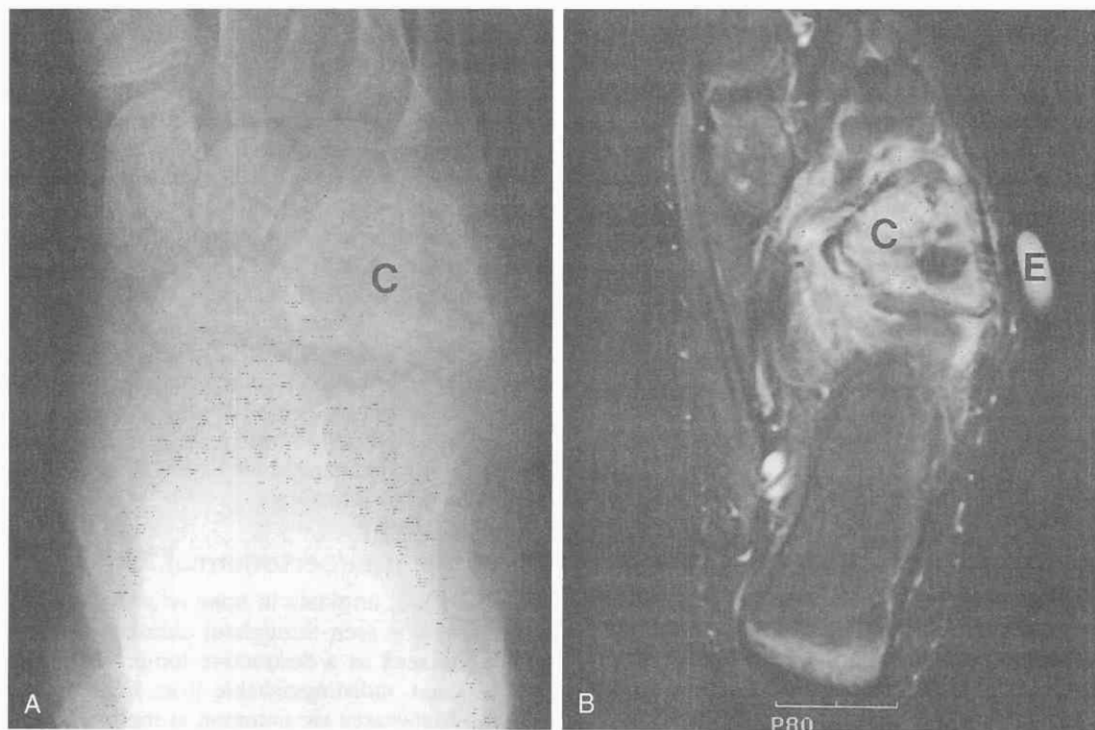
Ewing's sarcoma of the cuboid bone in an 8-year-old boy. A, Radiograph shows a lytic expansile lesion of the cuboid bone (C). B, Postgadolinium axial T1-weighted image (TR = 716 msec, TE = 14 msec) with fat saturation shows enhancing soft tissue replacing the cuboid (C). Areas of necrosis are seen as low signal intensity. The cortex of the cuboid is partially destroyed. Enhancement is seen within adjacent soft tissues as a result of peritumoral edema. E, vitamin E capsule.
